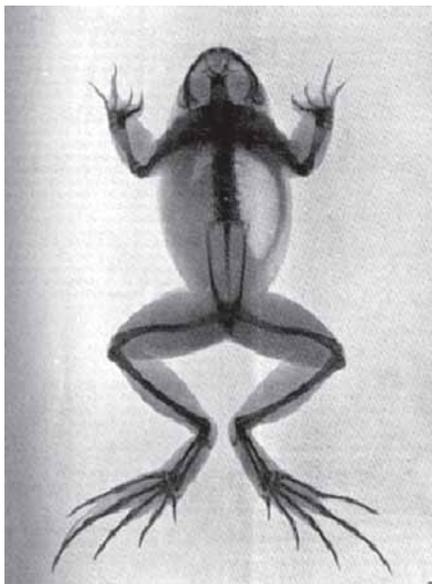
Röntgenogram of a frog (1896). There is no rib cage. Immediately following Röntgen's announcement of his eponymous rays, E. Waymouth Reid and Johannes Kuenen wrote, "The clearness with which the several bones have come out is so remarkable that we consider the picture well worth reproduction".<sup>10</sup> For years thereafter, the quality of a frog image was the measure of the resolving power of radiographic equipment. The image may have been the first published chest film; the authors did not explain the collapse of the left lung. The image is reprinted by permission from Macmillan Publishers Ltd.
